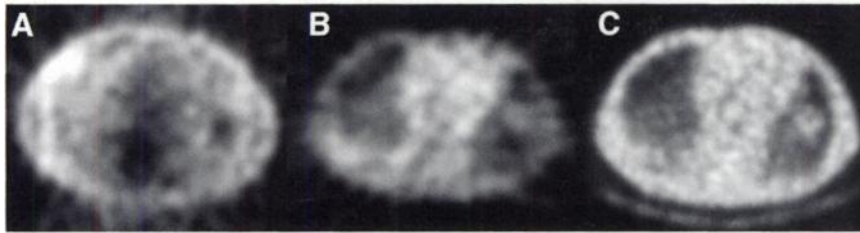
Single transaxial slice through chest of 55-y-old man injected with FDG. (A) Image was reconstructed without attenuation correction. Image (B) was reconstructed using attenuation map (C) obtained with ^{137}Cs transmission source.
